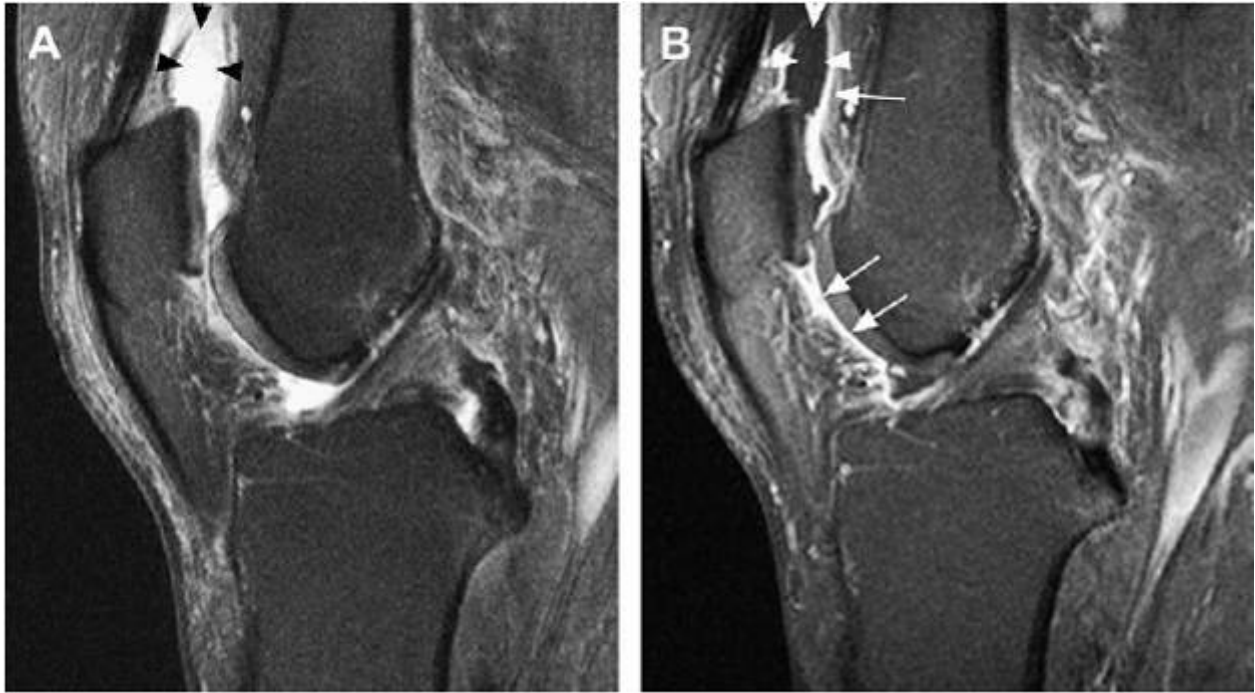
Synovial activation in knee OA. (A) Sagittal proton density-weighted fat-suppressed MR image shows joint effusion depicted as fluid-equivalent signal in the articular cavity (black arrowheads). (B) Sagittal T1-weighted fat-suppressed contrast-enhanced MR image of the same knee shows joint effusion depicted as hypointense signal within the articular cavity (white arrowheads). Supra- and infrapatellar synovial thickening is visualized (white arrows). Note that the true extent of synovial thickening can only be appreciated on T1-weighted contrast-enhanced MR images.
